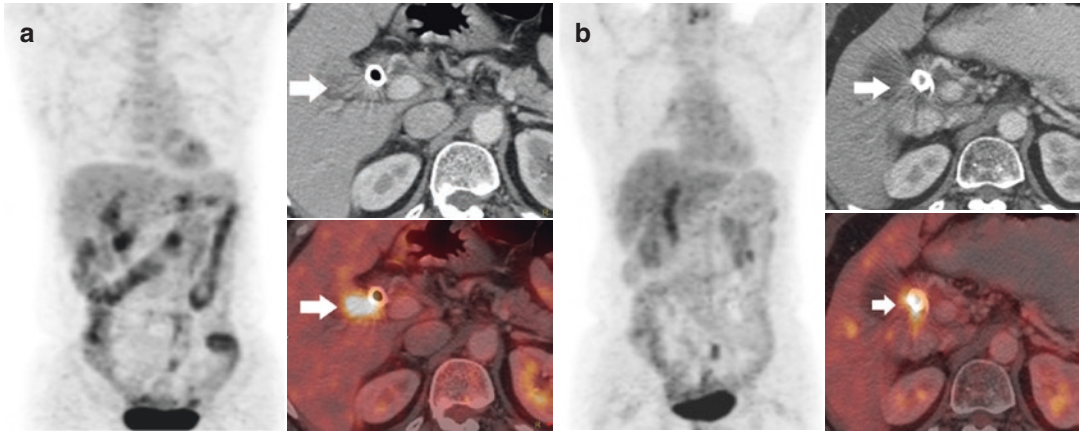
Partial metabolic response.  $^{18}\text{F}$ -FDG PET/CT (a) Staging scan shows FDG avid wall thickening in the fundus and body of gall bladder, involving parenchyma of adjacent right lobe of liver (SUVmax 13). (b) Post 4 cycles of chemotherapy, there is low-grade FDG avid
